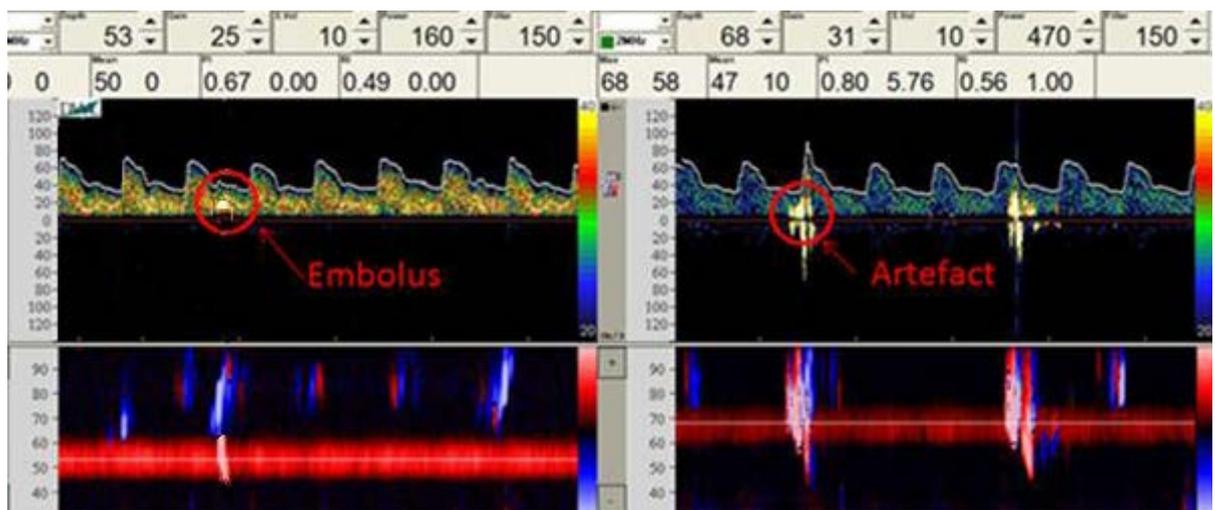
Doppler spectrogram showing the typical appearances of emboli and artefacts in the Doppler spectrum and Doppler M-mode display. This image is taken from a surgical recording of a patient recruited to our study.
